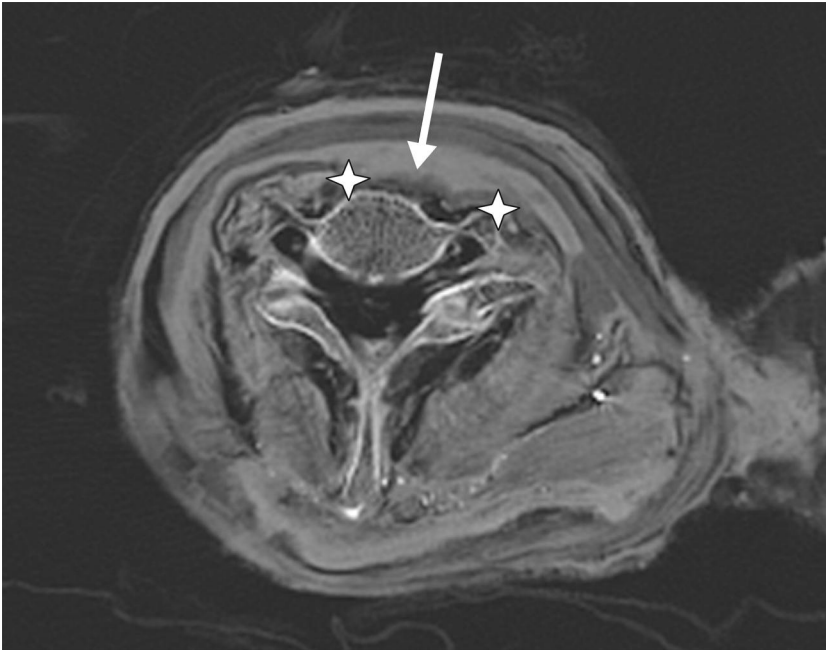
Axial CT section image of the neck of Ramesses III. Stars=wound margins. Arrow=homogenous embalming material seeping into wound and bone
